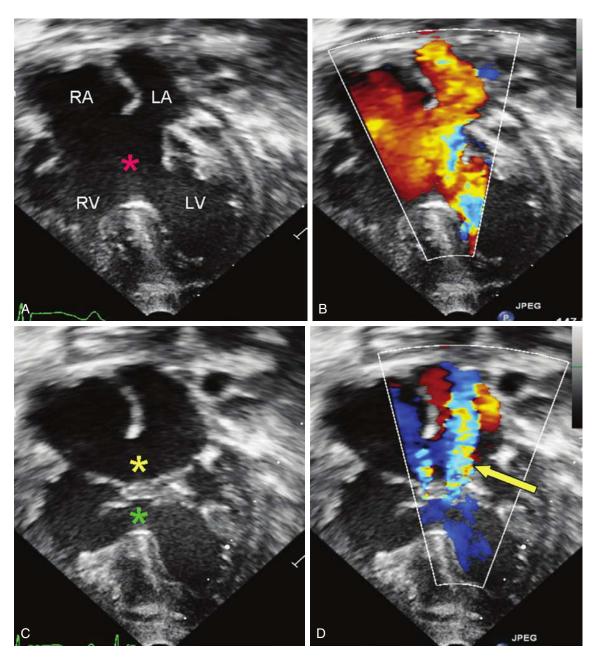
Complete atrioventricular (AV) septal defect (fourchamber view): A and B, Diastolic frames with and without color Doppler. Note large central defect (*red asterisk*) between atria and ventricles (A). Red Doppler flow indicates large atrial and ventricular shunt (B). C and D, Systolic frames demonstrate atrial (*yellow asterisk*) and ventricular (*green asterisk*) components of the defect (C). Blue Doppler flow (*arrow*) indicates valve regurgitation (D). LA, left atrium; LV, left ventricle; RA, right atrium; RV, right ventricle.
